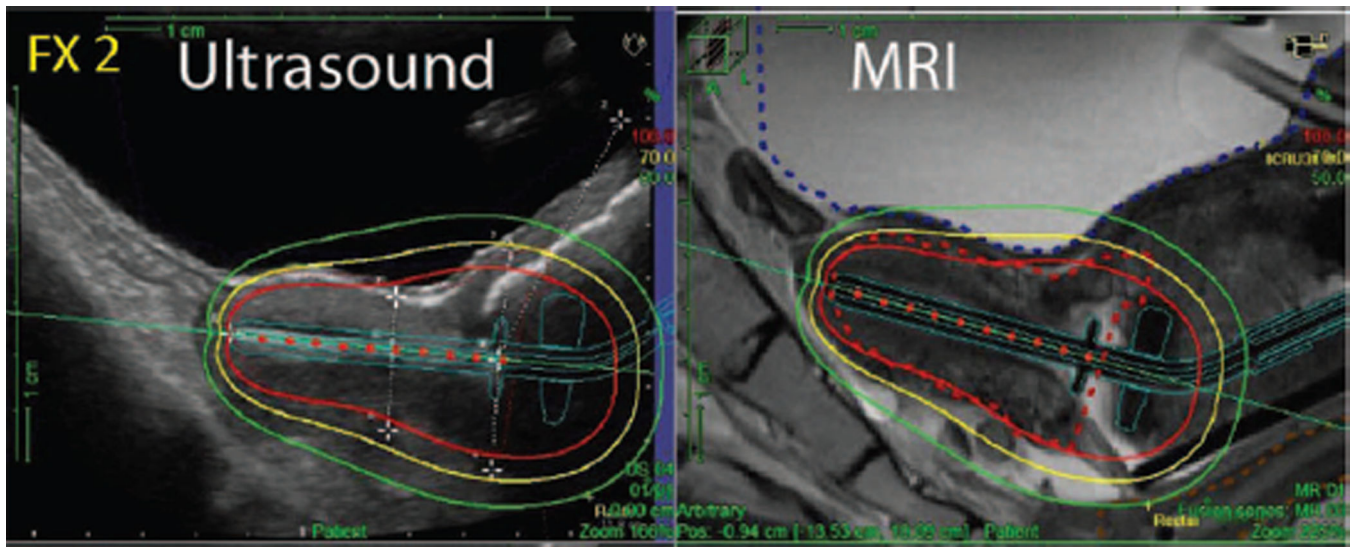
Ultrasound and MRI Images for Delivery of Brachytherapy
